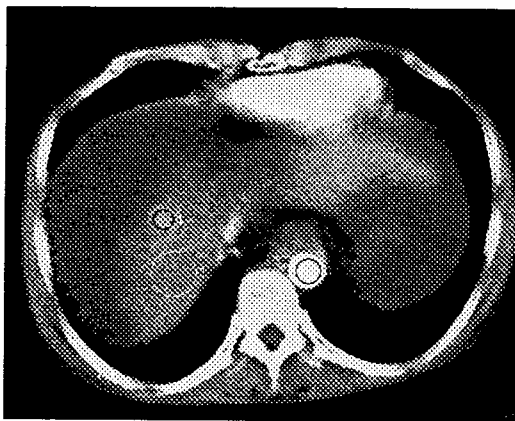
ROI selection to obtain CT number-time curve in liver Dynamic Scan Image. Using region of interest (ROI) cursors at the CT console, mean attenuation values for the tumor, hepatic parenchyma, aorta, and portal vein on each image of single-level bolus dynamic CT were recorded. ROI 1: Hepatoma, ROI 2: Hepatic parenchyma, ROI 3: Aorta
